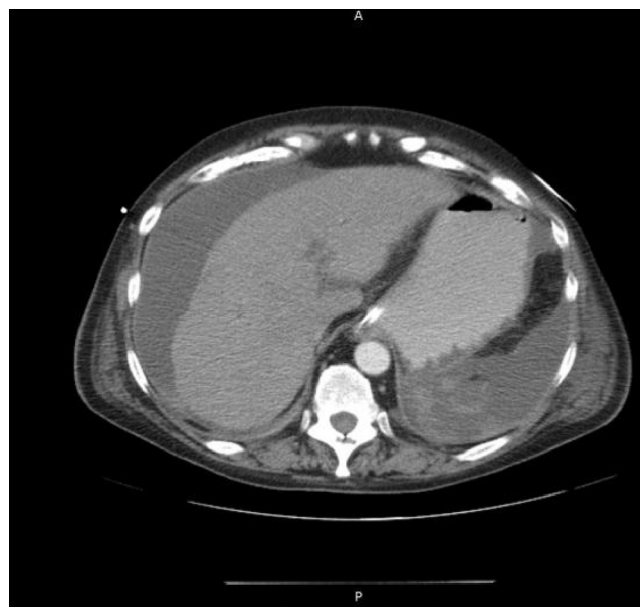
POD6 axial CT Abdomen with hyperdense area in LUQ.
